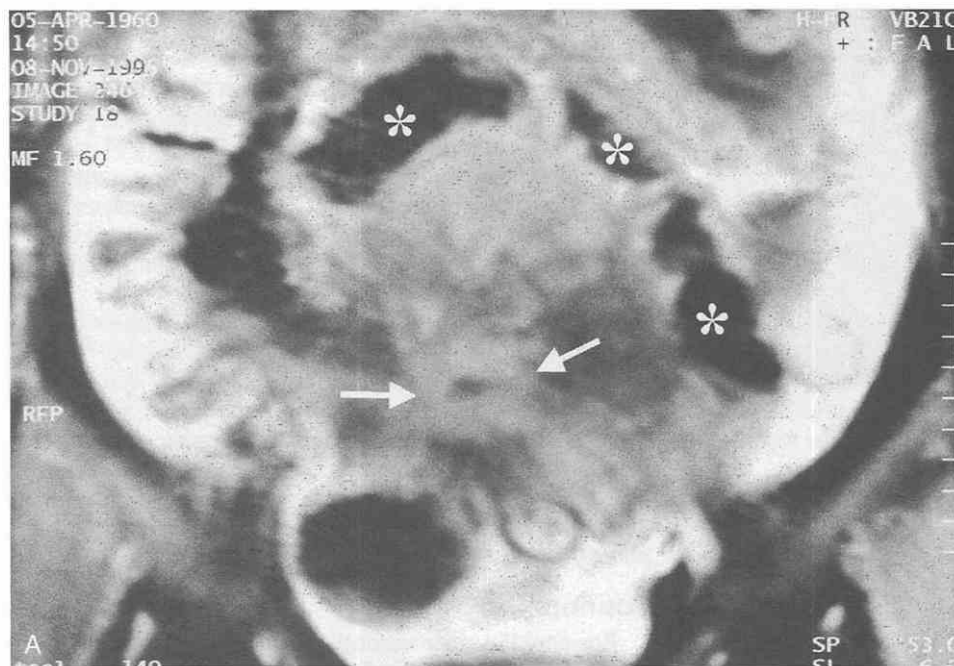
Crohn's disease with stricture. A, Coronal half-Fourier acquisition single-shot turbo spin-echo (HASTE) MR image shows irregular concentric bowel wall thickening and luminal narrowing (arrows) with diffuse inflammatory infiltration in the perienteric region. Bowel wall thickening is also present along the mesenteric border of the dilated small-bowel loop (asterisks). B, Multiplanar reconstruction images have the advantages of easy orientation of bowel wall and perienteric changes such as stricture (arrows), bowel wall thickening (arrowheads), and mesenteric infiltration (asterisks). (From Ha HK, Lee EH, Lim CH, et al: Application of MRI for small intestinal diseases. *J Magn Reson Imaging* 8:375-383, 1998.)
